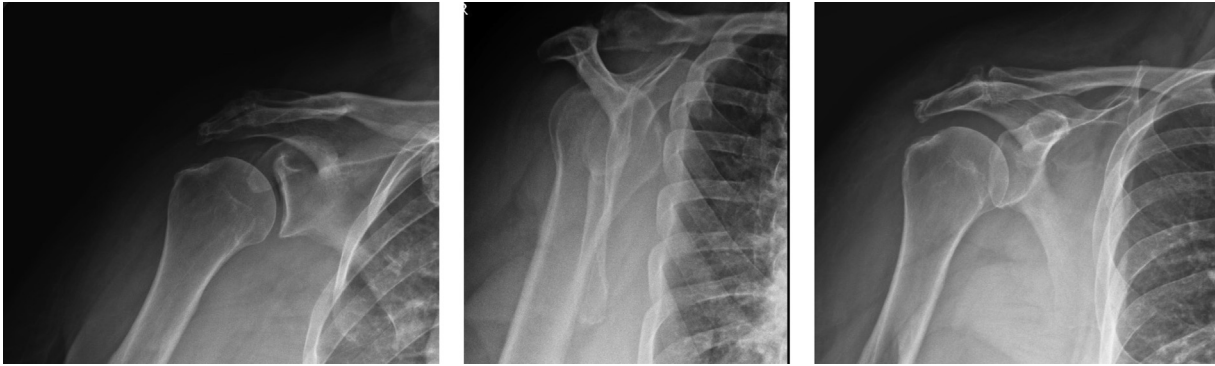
Preoperative radiographs of acromion fracture. Three views of the right shoulder. Imaging demonstrates a traumatic acromion fracture.
